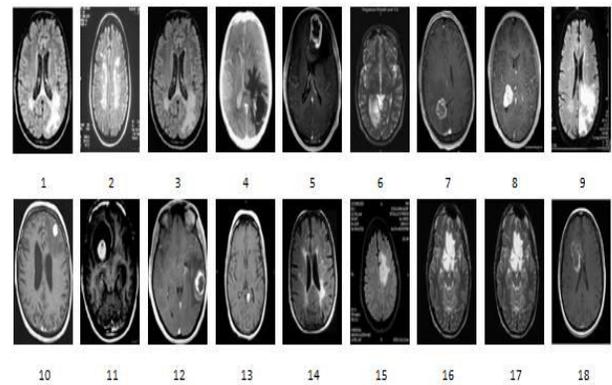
Brain MRI Images with Tumor
